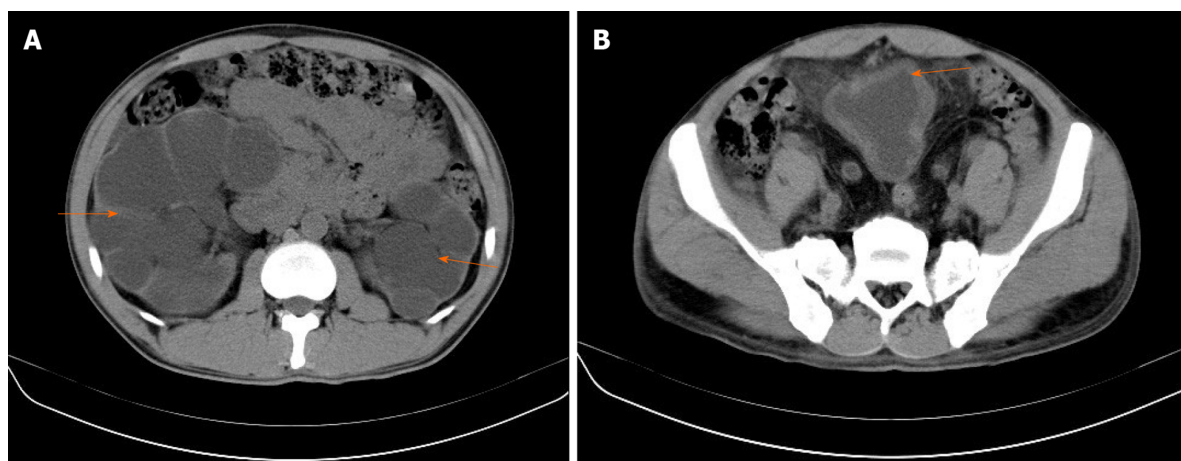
Computed tomography examination. A: Computed tomography showed bilateral hydronephrosis (orange arrow); B: A thick walled urinary bladder (orange arrow) with increased fat density around the bladder.
